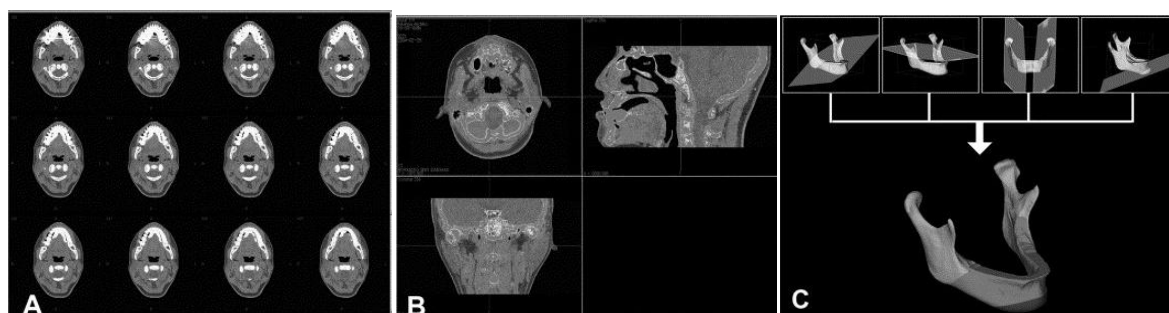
CT Digital Volume: A 2-dimensional CT images; B, segmentation; C, 3D model rendering
